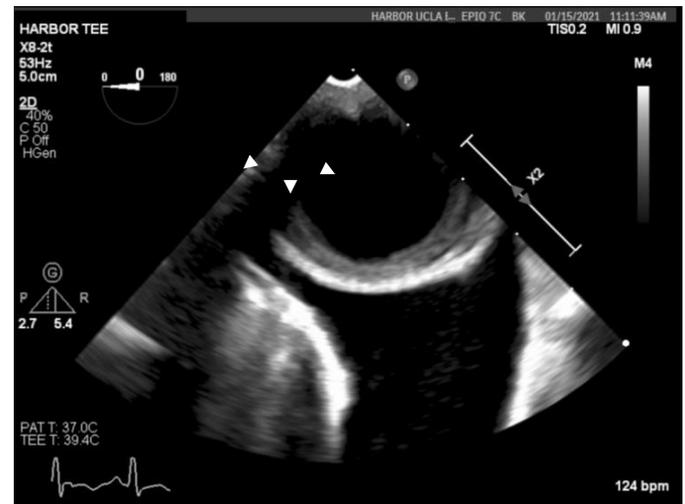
Transesophageal echocardiogram with 2-D imaging shows wall thickening (white arrows) around the circumference of the descending thoracic aorta.
